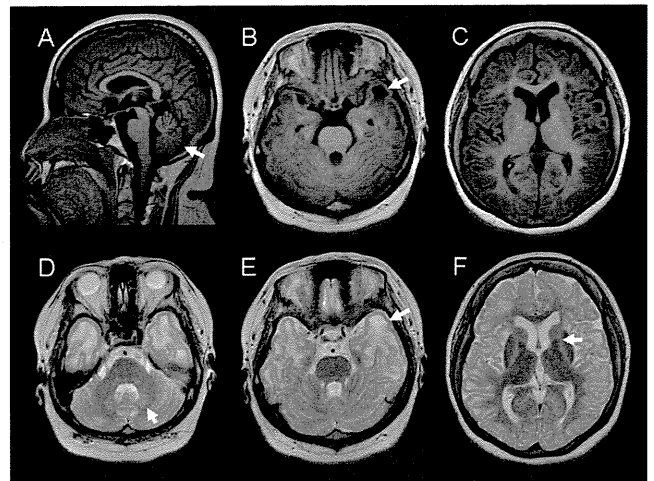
The results of the brain magnetic resonance imaging that was performed on the patient at 33 years of age. (A) A T1-weighted sagittal image shows remarkable folia of the cerebrum (arrow), indicating mild atrophy. (B and C) T1-weighted axial images. (D–F) T2-weighted axial images. Diffuse subcortical white matter abnormalities are noted in axial images. Some of the subcortical regions (arrows) show cystic changes (B and D). The involvement of the dentate nucleus (arrow) is characteristic (D). Signal high intensity is shown in the anterior and posterior limbs of internal capsule (F). Dilatations of the lateral ventricles and extra-cerebral spaces indicate diffuse brain atrophy.
